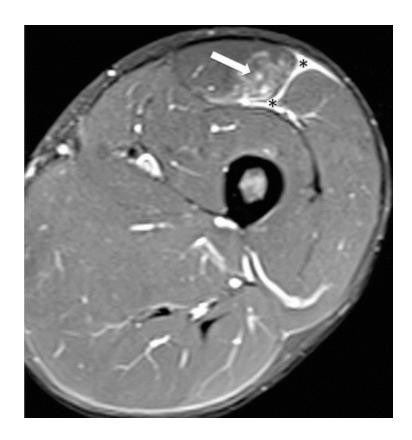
A 35-year old male athlete with a peripheral myotendinous injury of the right rectus femoris in. Axial fat-suppressed T2-weighted MRI shows a peripheral hyperintensity within the mid-belly of the rectus femoris associated (*arrow*) with fluid collection between the rectus femoris, vastus lateralis and vastus intermedius (*asterisks*). These findings are in keeping with grade II peripheral strain
